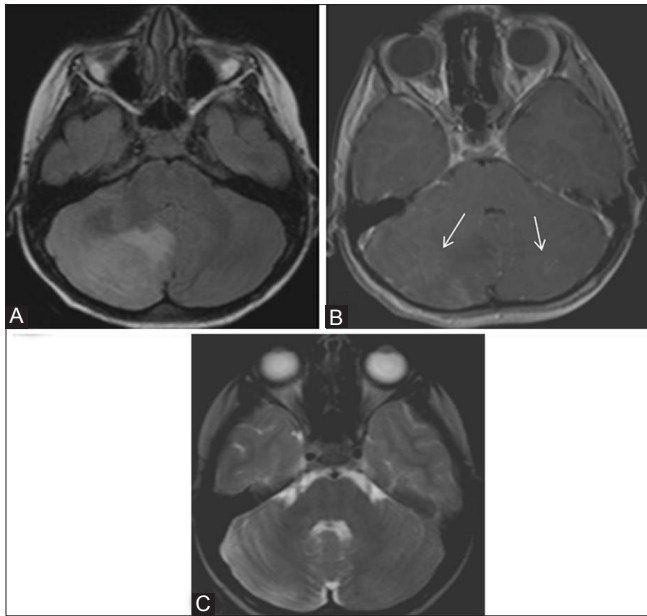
(A-C): A 16-year-old female with viral cerebellitis. (A) Axial T2W FLAIR image showing diffuse bilateral cerebellar edema (right side more than left side) (B) Axial T1W post-contrast image showing subtle patchy enhancement (C) 3 months follow-up axial T2W image showing complete resolution of the edema and mass effect
